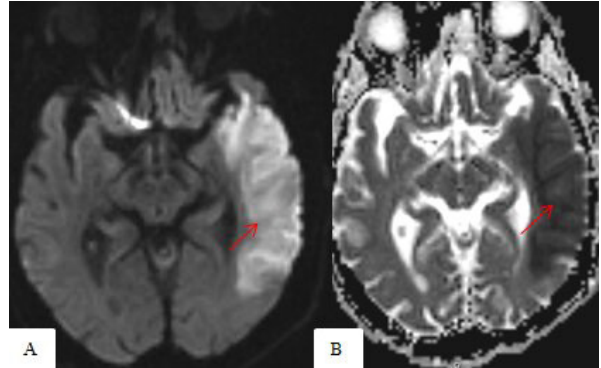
A 72-year-old male patient with T2DM, HT, obesity and smoking history presented with COVID-19 pneumonia and followed in ICU. A) DWI and B) ADC mapping of the brain show restricted diffusion at the left MCA territory characterized with hyperintensity on DWI (A, arrow) and corresponding low signal intensity on ADC mapping (B, arrow) compatible with AIS
